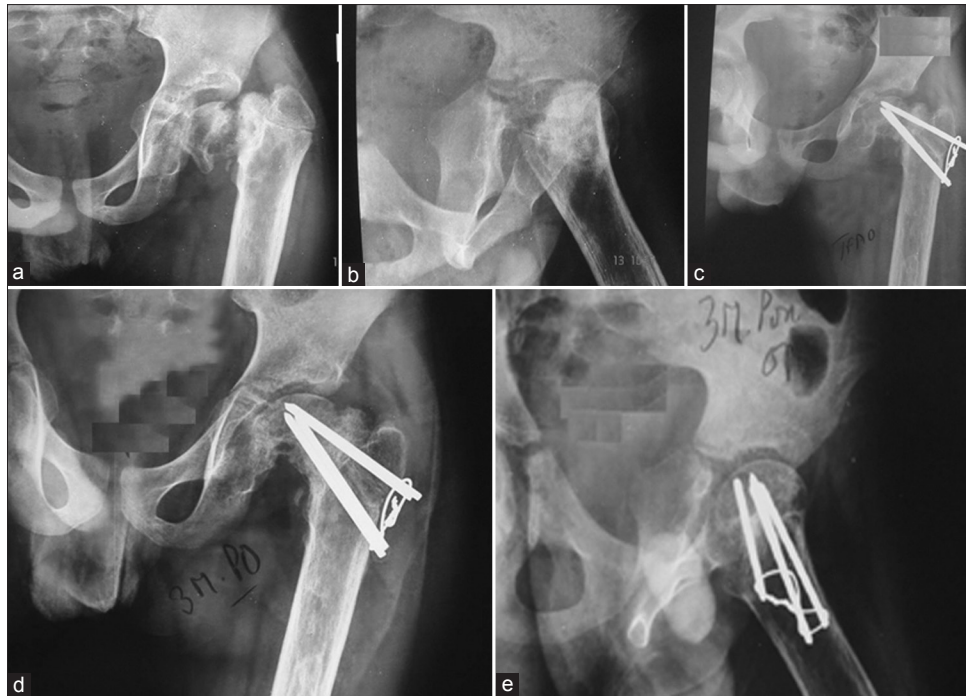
X-ray left hip joint anteroposterior and lateral views in an 11 year old male child showing (a,b) nonunion following sequel of chronic osteomyelitis, note the varus angle of neck of femur at 90°, (c) TFAO done (d) union achieved at three months postoperatively; neck shaft angle restored to 125° (e) lateral view at 3 months postoperatively showing union
